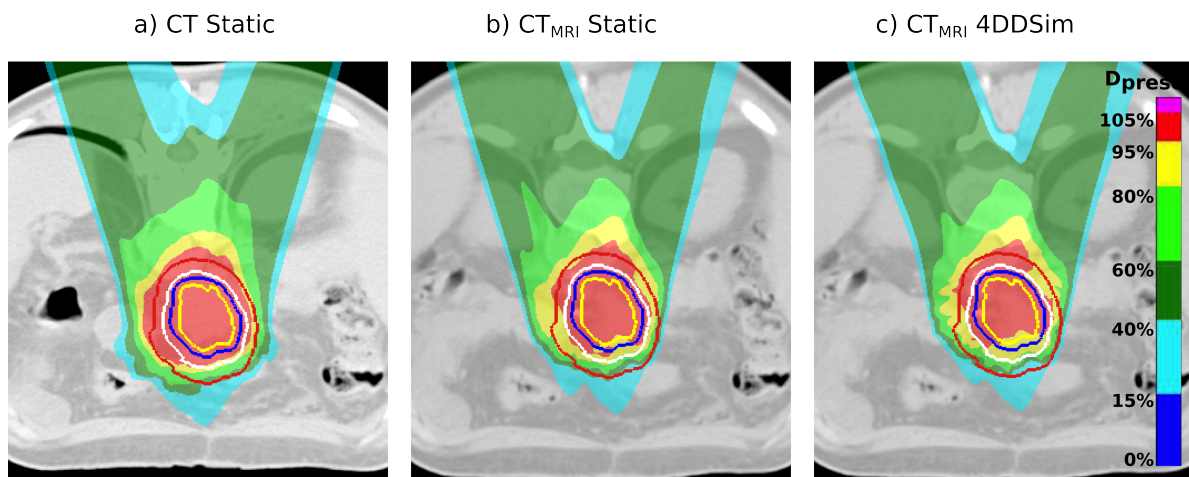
Transversal view of the dose distribution for patient H13 in the CT and CT_{MRI-0} static case and in one of the 4DDSim scenarios. GTV, CTV,ITV and PTV are represented in yellow, dark blue, white and red, respectively.
